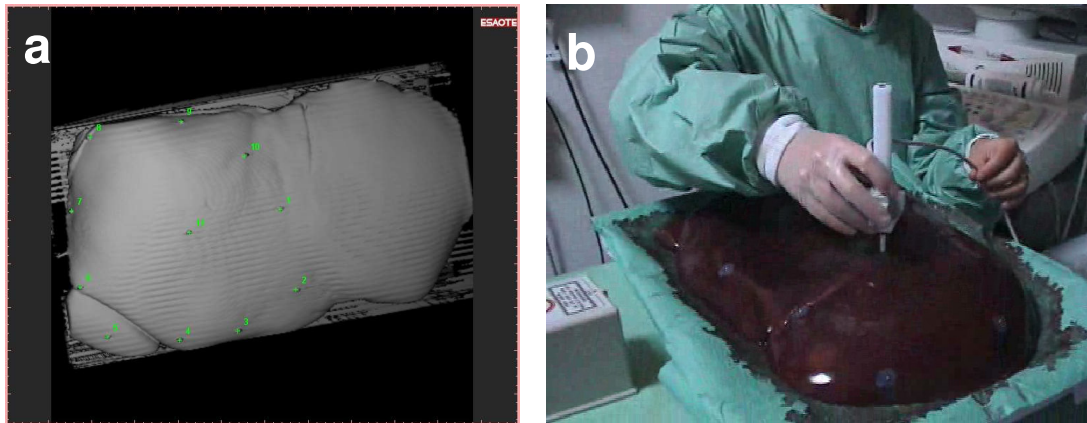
(a-c). The positions of all the fiducial markers in the CT volume were identified and numbered (a). Then the corresponding positions on the calf livers are matched by applying point contact with a registration pin (b) from the system on each marker. Accuracy or error of registration is displayed by the system following completion of registration of all the 10 positions (c).
